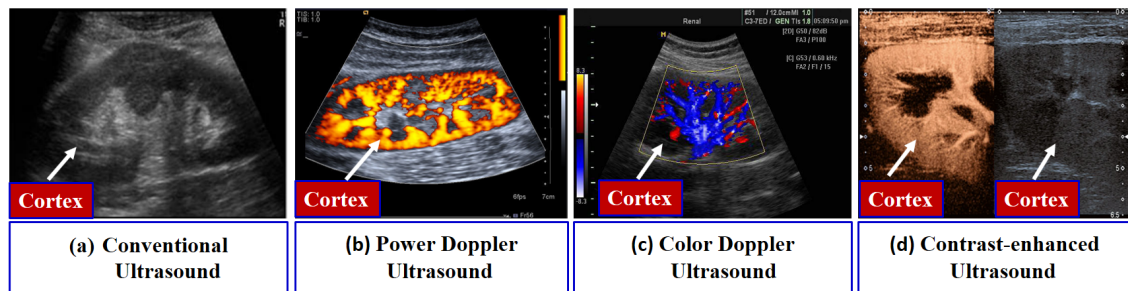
An example of different ultrasounds.
